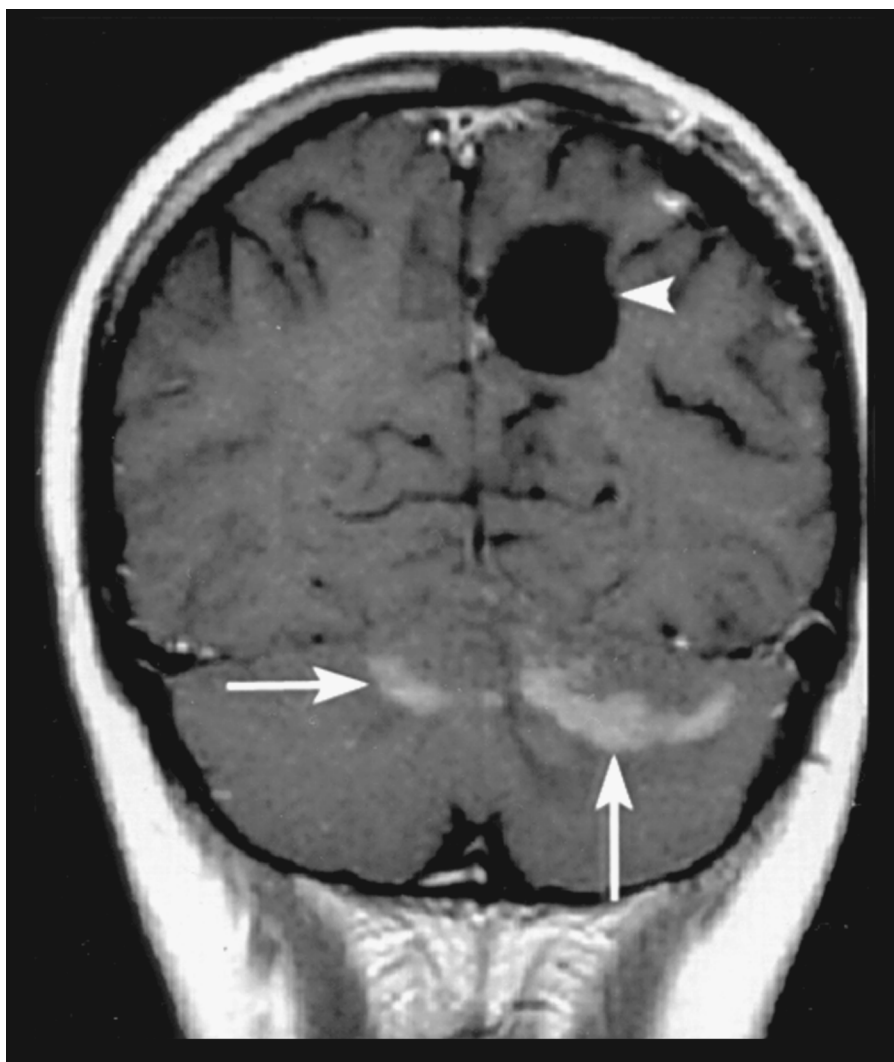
Post-contrast coronal T₁-weighted MRI of the brain shows radiation necrosis of the cerebellar hemispheres (arrows) that developed after resection of a parietal lobe glioblastoma and accelerated radiation therapy with chemotherapy to the brain (arrowhead points to the surgical cavity).
